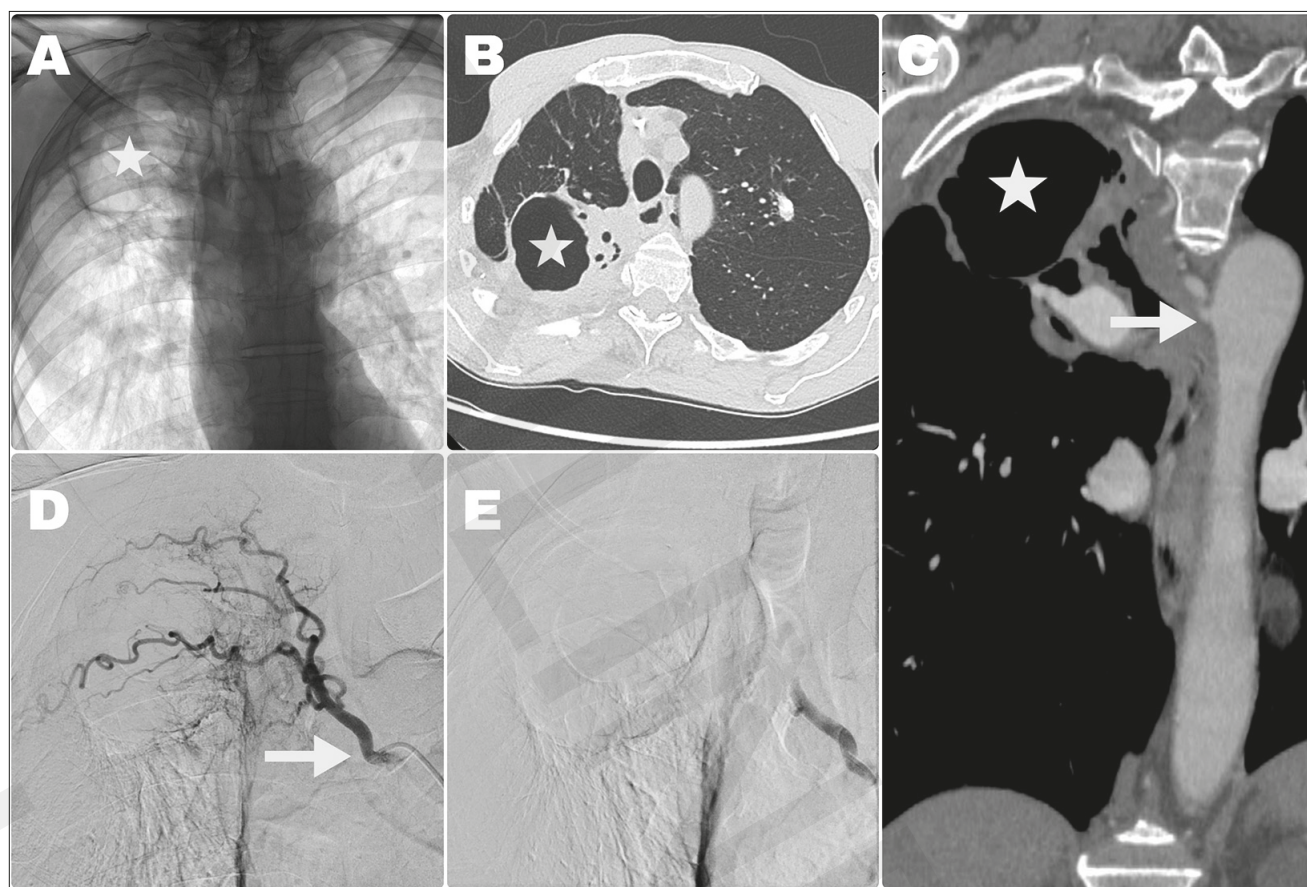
Chest X-ray (A) and CT (B,C) presenting a cavity in the apex of the right lung (white star). Culprit vessel originating from aorta was detected on the contrast-enhanced images (white arrow). Selective angiography disclosed rich blood supply with vascular blush characteristic for patients presenting with haemoptysis (D – white arrow). Control contrast injection confirmed complete occlusion of the vessel and exclusion of the blood supply to the lesion
